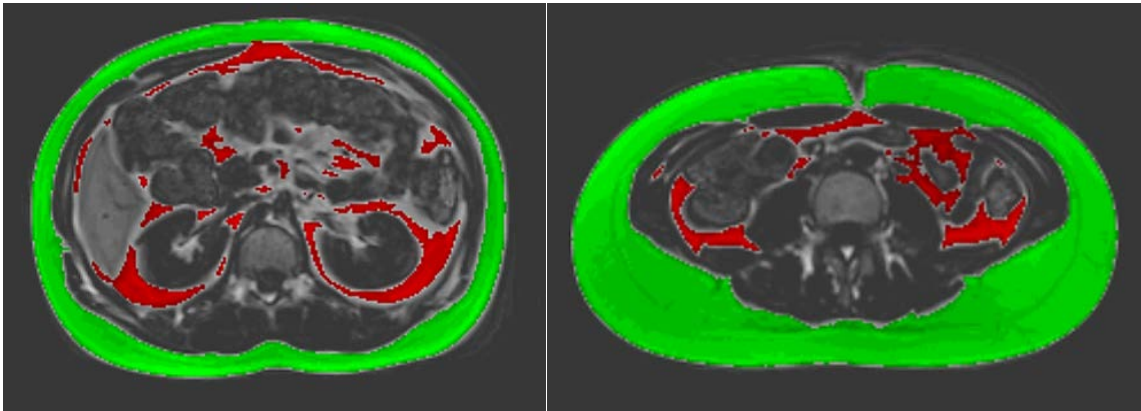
Images obtained from MRI for adipose distribution and VAT:SAT calculation. Subcutaneous fat is coloured green, and visceral fat is red. Image on left is a male with A-T, while the image on the right is a female control.
